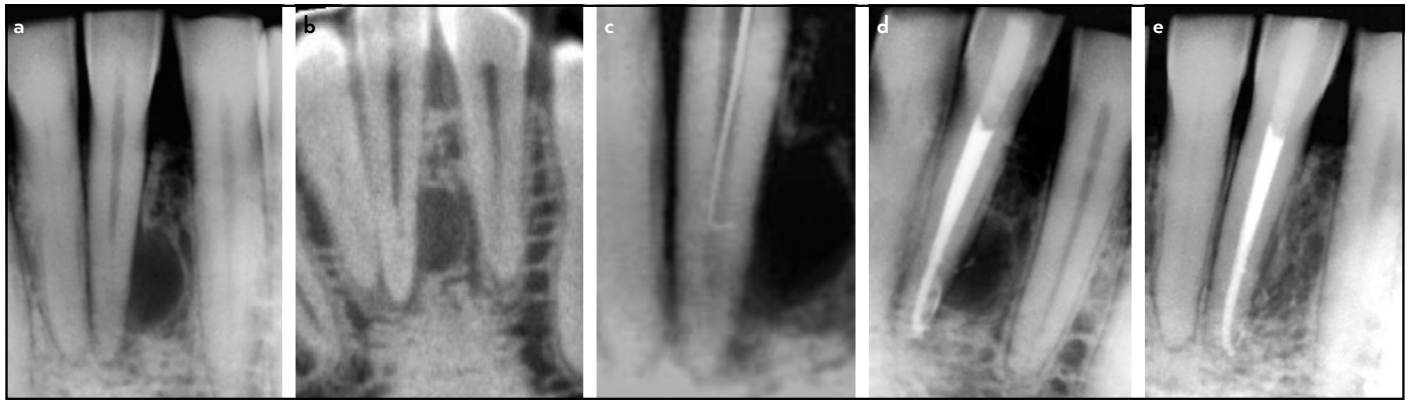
Case 6, tooth 21, necrotic pulp with apical and lateral periodontitis. (a) initial; (b) instrument in the lateral canal; (c) after root canal filling; and (d) 3-year follow-up radiographs
